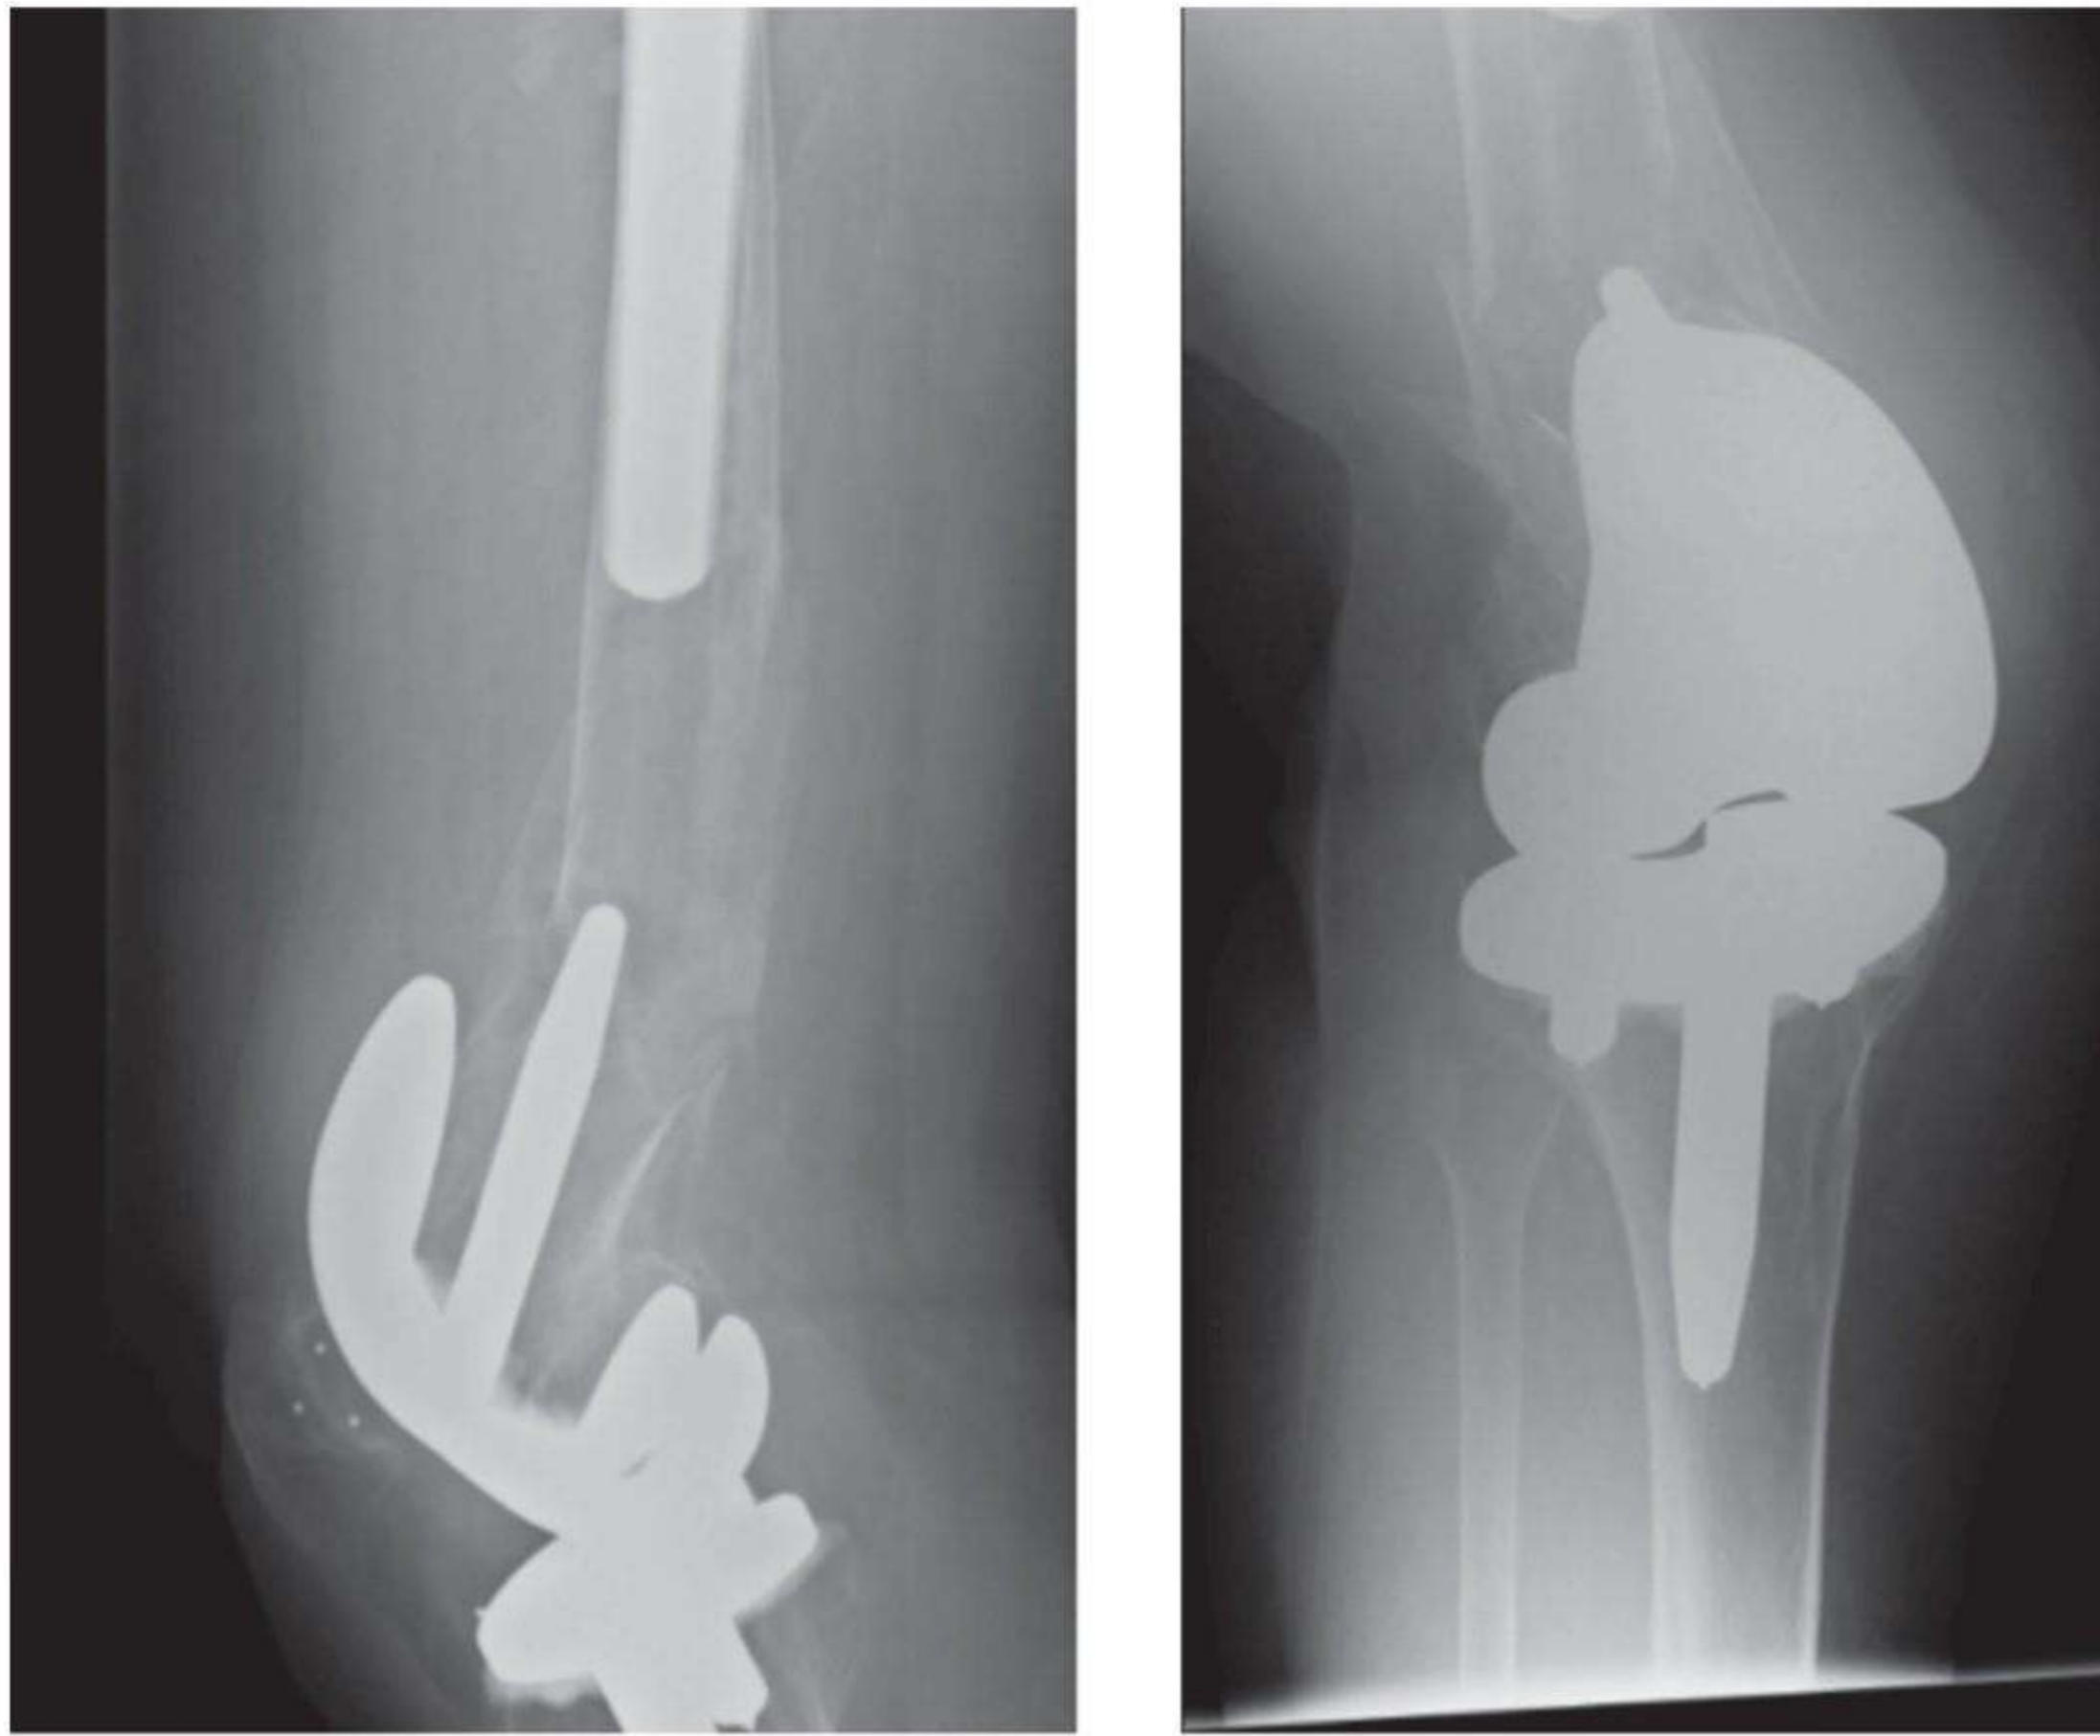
AP and Lateral radiograph of knee
